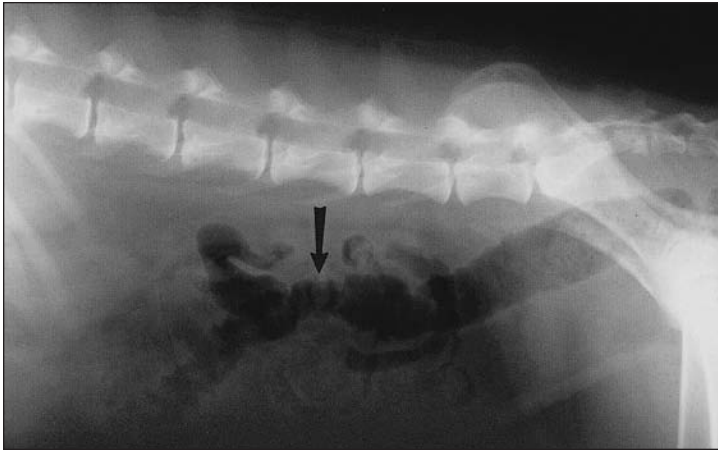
Same radiographic views as in Figure 1. The colon appears hypersegmented (arrow) and the duodenum is distended and gas filled (arrowhead).
